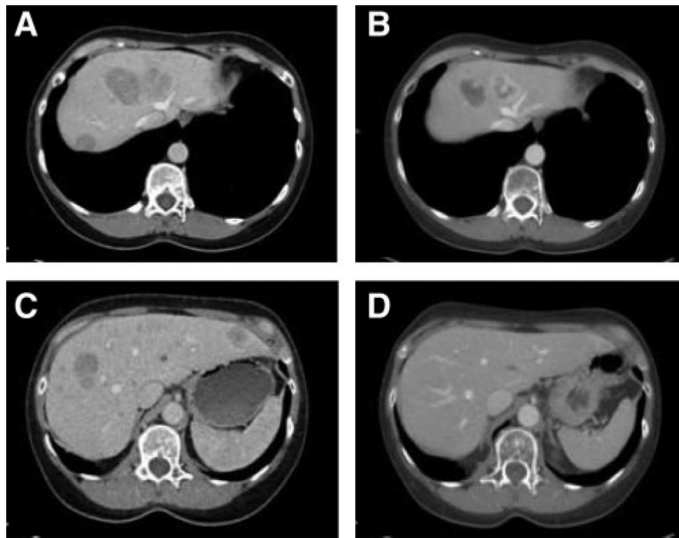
Comparison of baseline (A and C) CT scans of the abdomen and CT scans performed 10 months after initial diagnosis (B and D) in a 48-yr-old female with a malignant insulinoma treated with [^{177}Lu]octreotate showing partial response of the liver metastases (case 2).
